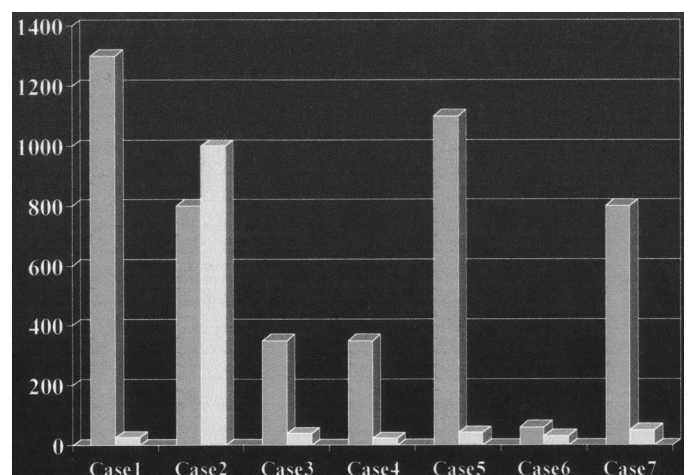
Preoperative and postoperative post-void residual volume in ml assessed by sonographic scan in all cases.
